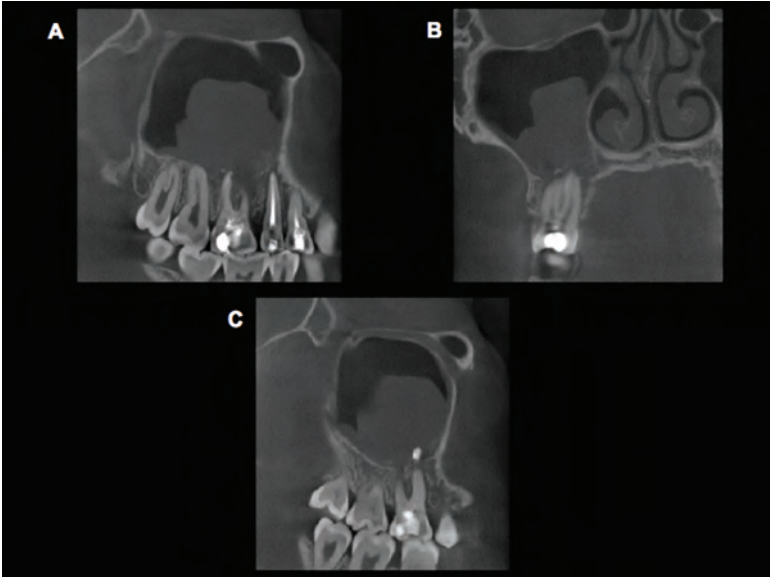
A, The sagittal CBCT plane exhibited a proliferation of soft tissue in the right maxillary sinus, ranging from the first premolar region back to the second molar area. The mesiobuccal and to a lesser extent the distobuccal roots of the first molar exhibited resorptive signs, and the floor of the sinus was not visible in that area. B, The coronal CBCT section showed a proliferation of soft tissue in the right maxillary sinus, occupying the basal third of the sinus. C, Another sagittal CBCT section shows a foreign, radiopaque material present at the tip of the mesiobuccal root. Bornstein MM et al. J Endod 2008;34(12): 1549–53. Reproduced with permission.
